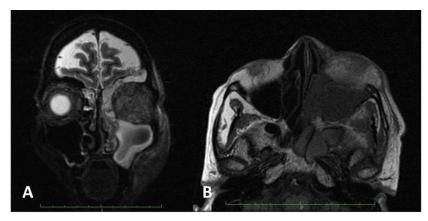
T2W coronal (A) and T1 W axial (B) MRI reveals mucosal thickening in left maxillary sinus and frontal sinuses
